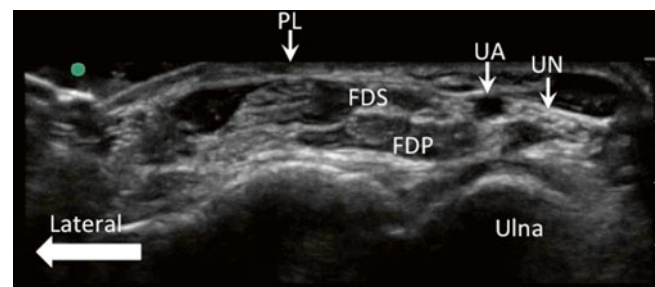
Sonogram of the ulnar nerve just proximal to the carpal tunnel. At this level, the ulnar nerve (UN) is on the ulnar side of the ulnar artery (UA). FDS flexor digitorum superficialis, FDP flexor digitorum profundus, PL palmaris longus (Reproduced with permission from Philip Peng Educational Series)
